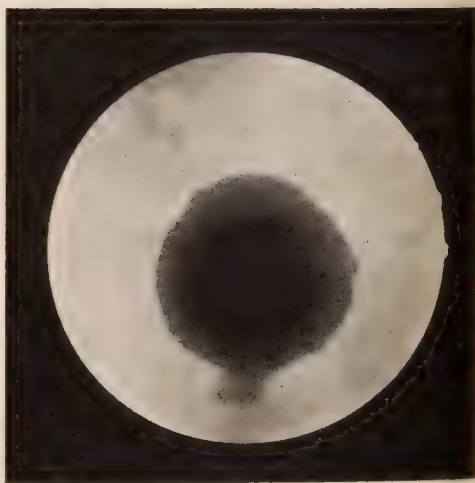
Roentgenogram of enucleated eyeball, showing the wire near optic nerve. Case No. 3. (The enucleated eyeball and X-Ray plate were shown at the meeting.)
